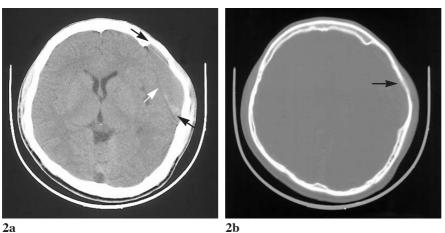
a. Non-contrast enhanced CT scan of brain taken 6 days after spinal surgery showed relatively hyperdense hematoma in the left fronto-parietal area (arrows). One hypodense band-like structure within this hematoma (white arrow) was supposed to be the medial wall of preexisting arachnoid cyst which separated the intracystic hematoma from the adjacent SDH. b. CT image of brain in bone window setting showed erosion at calvarium (arrow). The SDH was likely due to rupture of the adjacent arachnoid cyst.
